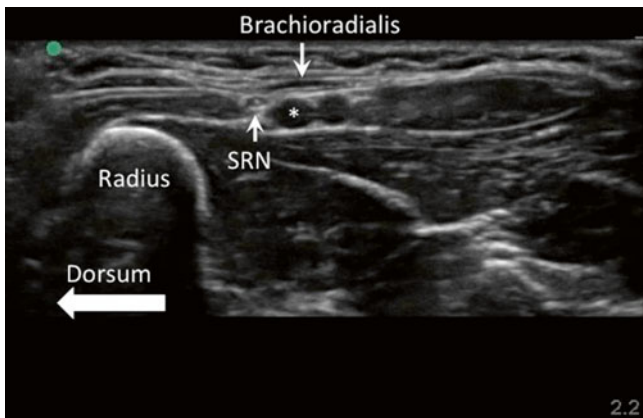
Moving the ultrasound probe distally compared to the position in Fig. 35.9. The brachioradialis muscle become tendon the superficial branch of the radial nerve (SRN) is seen coming out to the dorsal surface of the forearm. The radial artery is indicated with *asterisk* (*) (Reproduced with permission from Philip Peng Educational Series)
